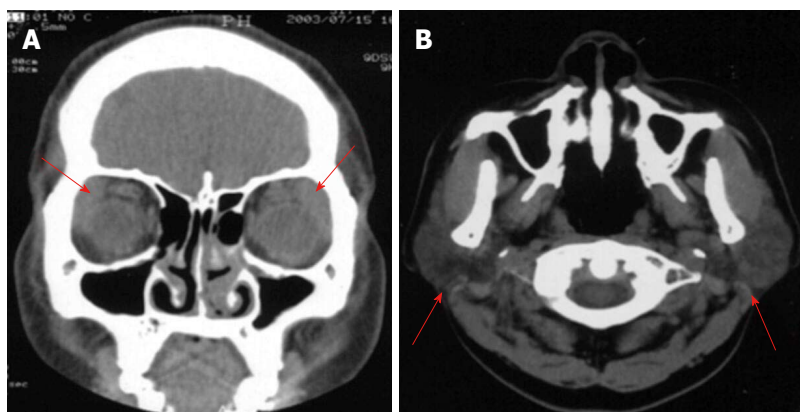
Involvement of the lacrimal gland parotid gland. A: Computed tomography (CT) showing double lacrimal gland swelling on both sides; B: CT showing enlargement of the parotid gland.
